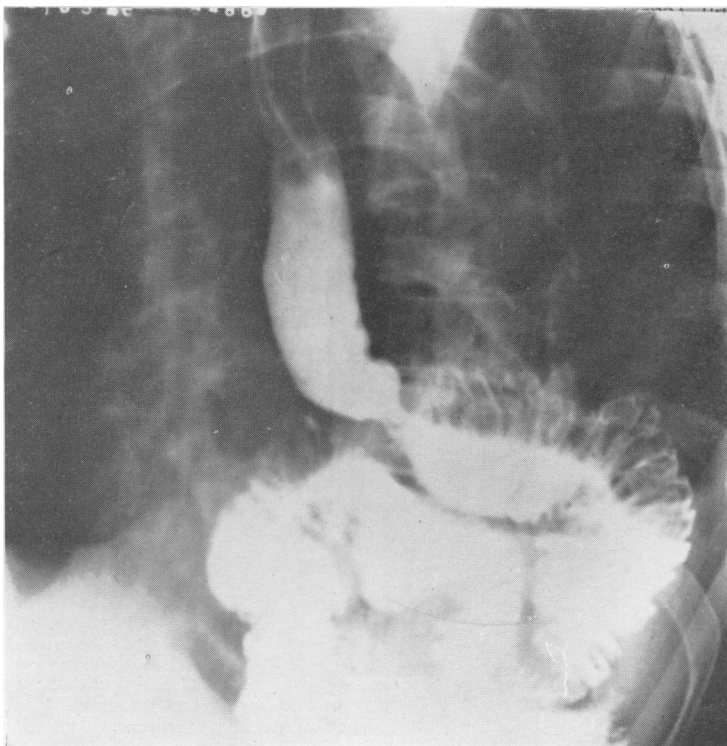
Transthoracic oesophagojejunostomy after total gastrectomy and oesophagectomy for carcinoma of cardia. Patient working and taking normal meals.
